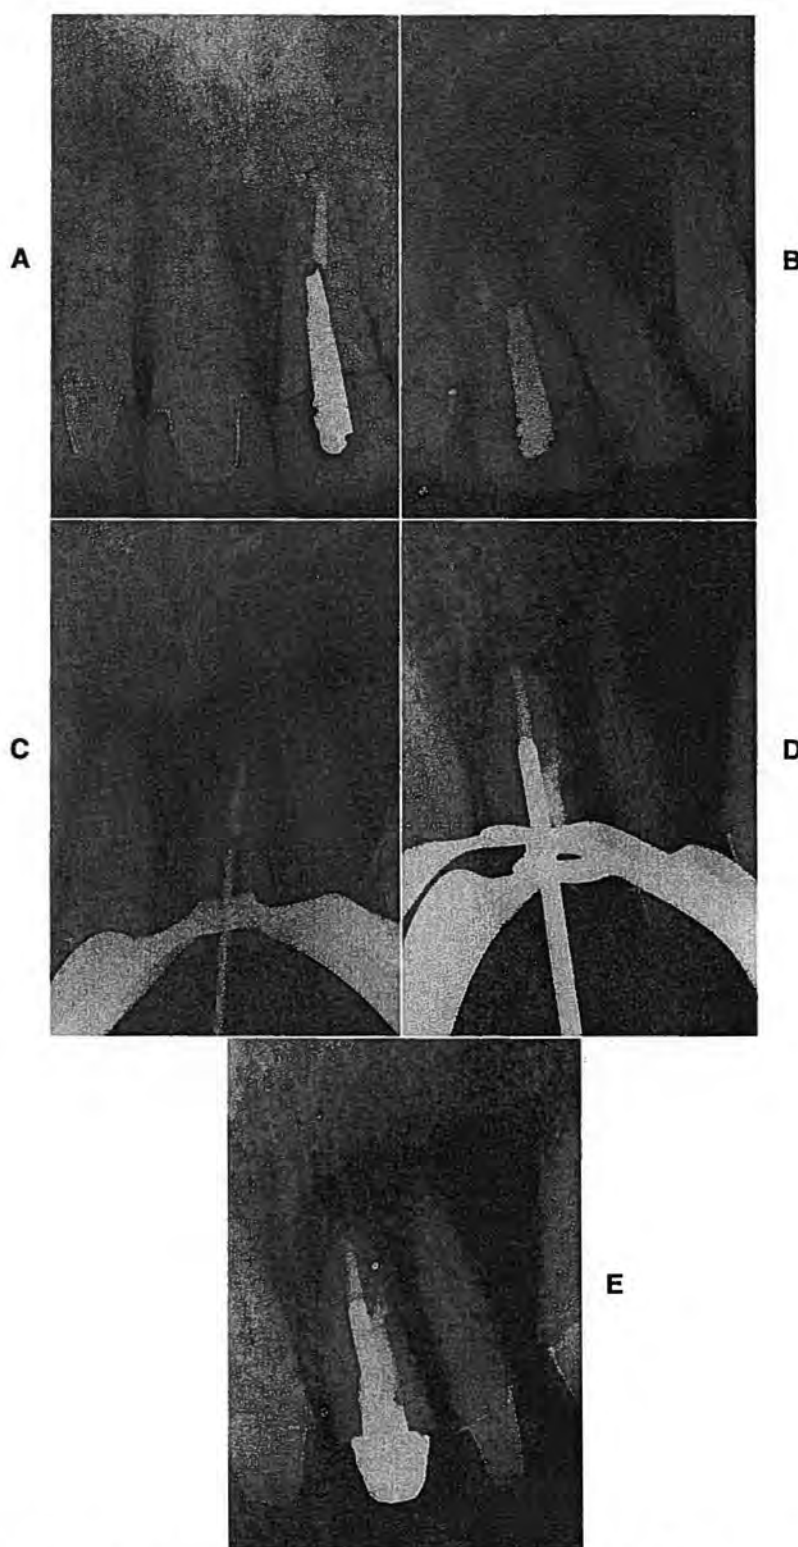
Tooth with perforation treated by filling with gutta-percha. A, Radiograph of anterior area with post and porcelain jacket crown. Post appears to be in canal, but the patient had a sinus tract on the palate, and I suspected a perforation. B, Angled view from distal verifies perforation to the palate. C, Crown and post were removed, and distance to perforation was measured with a file to slightly short of sensitivity by the patient. D, That false canal was filled with laterally condensed gutta-percha and Wach's paste, and an Endopost measured adjacent to it. E, Two years later the tract has not returned, and the tooth is comfortable. (Restorations by Dr. Don Hackman, formerly of Chicago.)
